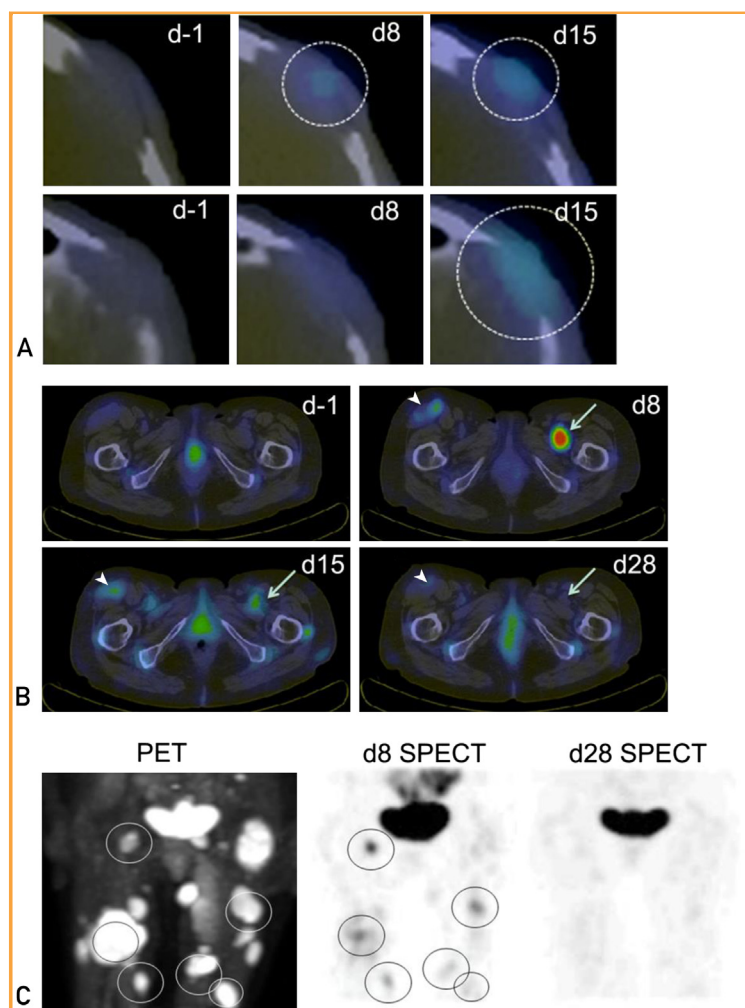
Intratumoral propagation of systemically administered MV-NIS. A, Serial single-photon emission computed tomography (SPECT)—computed tomography (CT) images from patient 1 at baseline (d-1) and on days 8 (d8) and 15 (d15) after MV-NIS infusion at the level of the left frontal plasmacytoma. Two adjacent transaxial slices from 6 hours after isotope administration are shown for each time point. There is a small area of increased uptake in the plasmacytoma visible in the lower slice on the day 8 scan (circle). This area of increased uptake is more extensive, and visible in both slices (circles), on the day 15 scan. B, Serial SPECT-CT images from patient 2 at baseline and on days 8, 15, and 28 (d28) after MV-NIS infusion at the level of the inguinal region. Compared with the baseline images, there is greatly increased radioiodine uptake in a deep-seated intramuscular plasmacytoma in the right hemipelvis on day 8 after MV-NIS administration, which is diminishing by day 15 and is back to baseline by day 28 (arrows). On the same transaxial slices, there is moderately increased radioiodine uptake in the large left inguinal lymph node on day 8, which again is diminishing by day 15 and back to baseline by day 28 (arrowheads). C, Anteroposterior fluorodeoxyglucose positron emission tomography (PET)—CT image obtained before MV-NIS administration and the corresponding iodine I 23 SPECT-CT images obtained 8 days and 28 days after virus administration. All areas of intense radioiodine uptake (aside from the bladder) in the day 8 SPECT-CT scan are seen to correspond to glucose-avid plasmacytomas in the PET-CT image (circles).
